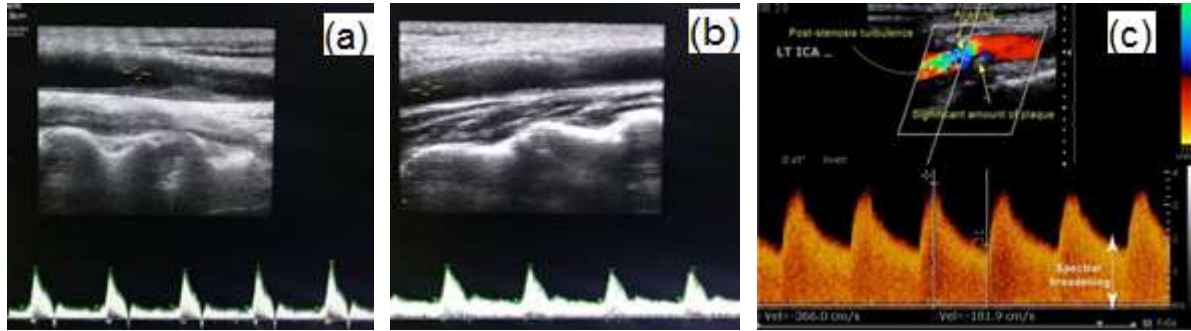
(a), (b) Doppler US finding of (a) CCA with an atheromatous plaque causing increased PSV, (b) increased PSV with spectral broadening in the post stenotic segment of CCA, (c) Duplex US image showing severe stenosis (70% to near occlusion) of the ICA.
